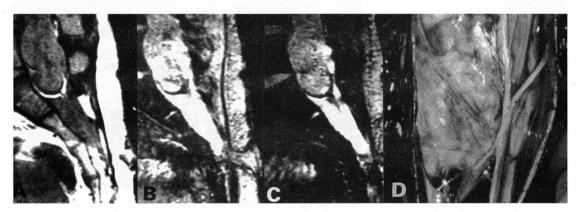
A: Lumbosacral spine MRI (T1 weighted image, sagittal) of case 4 showing an intraspinal mass and the CDS tract from the lower end of the mass to the skin. B and C: Gradient echo showing the skin lesion and part of the tract more clearly. D: Operative photograph demonstrating an intraspinal mass and laterally displaced cauda equina.
